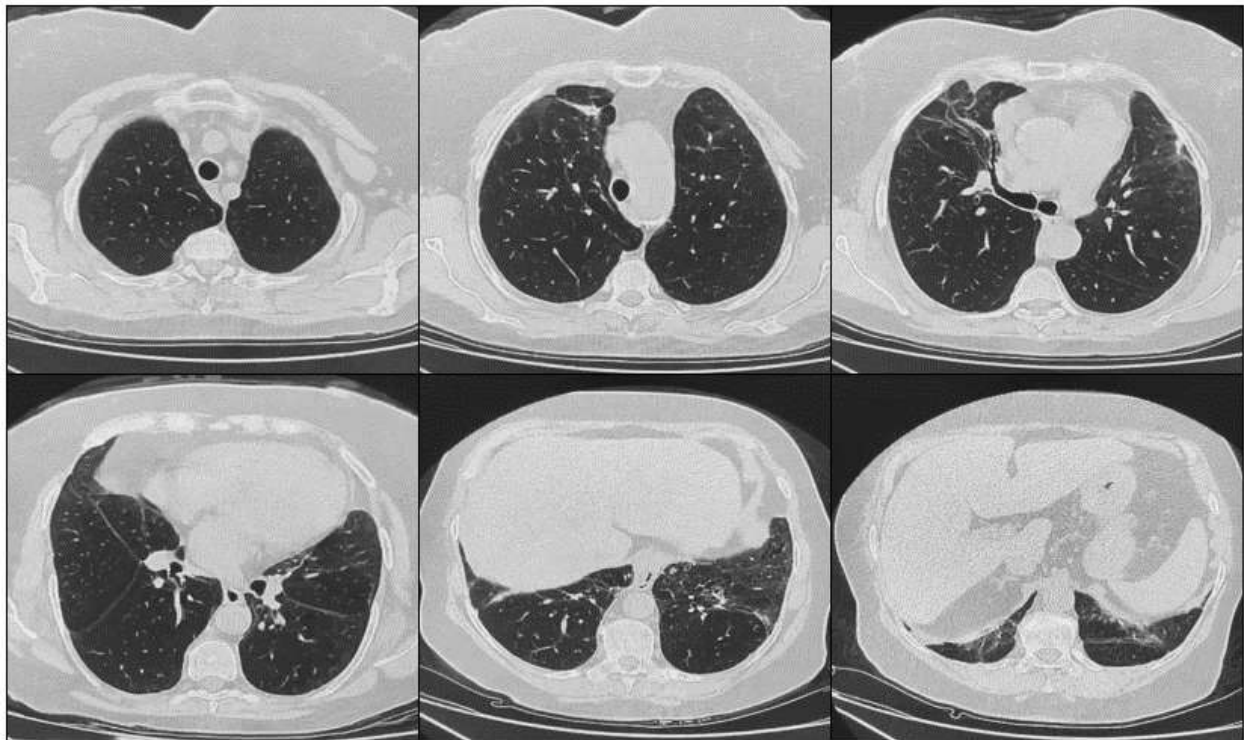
Follow-up high-resolution chest computed tomography after corticosteroid therapy and mycophenolate mofetil showing marked regression of bilateral interstitial abnormalities, particularly ground-glass opacities and septal thickening, without progression of fibrosis. Persistent bronchiectasis and traction bronchiolectasis are noted, with disappearance of the pericardial effusion.
